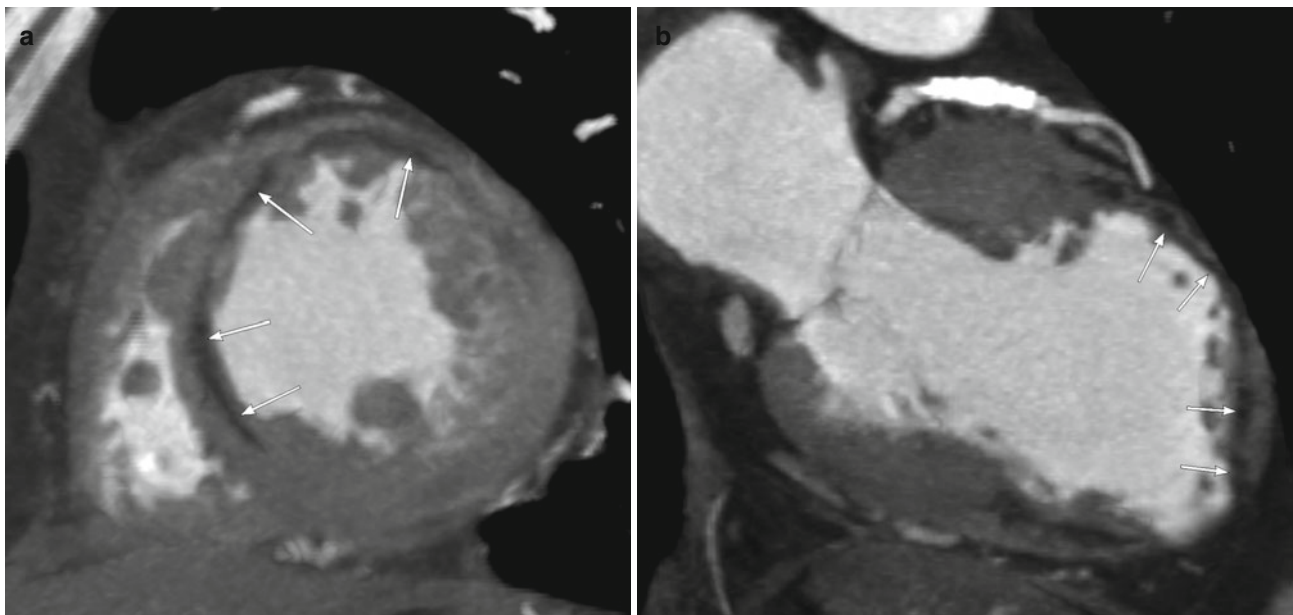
CT of a patient with myocardial fat scarring by healed MI. Cardiac CT (short-axis and 2-chamber views) shows subendocardial myocardial fat scarring (*arrows*) at mid- to apical anteroseptal wall
